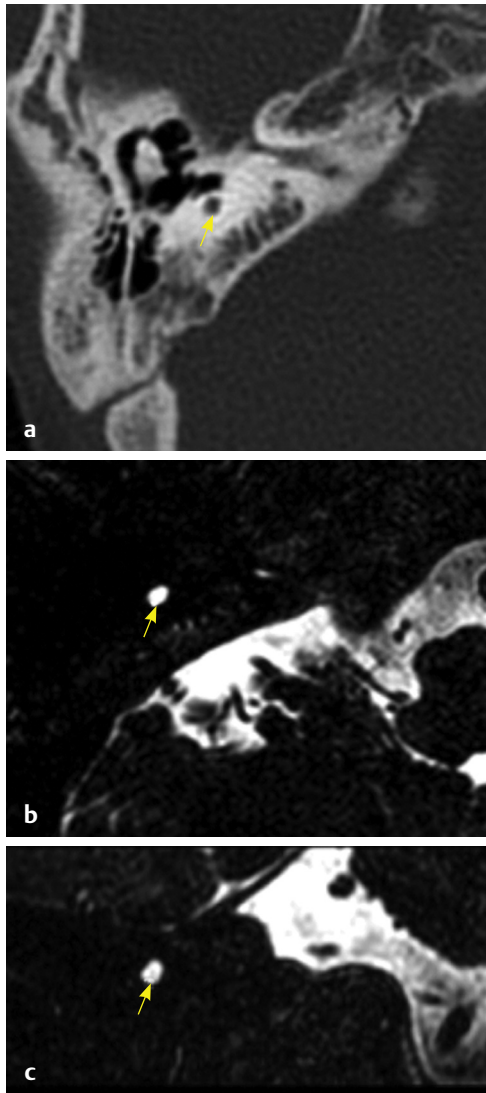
(a) HRCT temporal bone, axial section bone window and (b) axial section and (c) coronal sections on MRI, CISS sequence show RO (yellow arrow) without internal acoustic canal.
